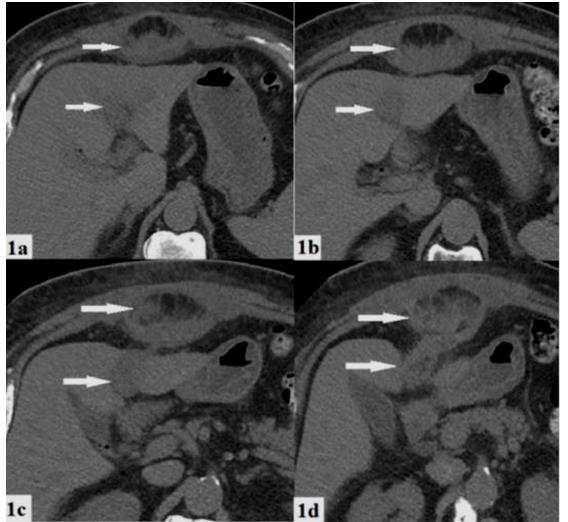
The falciform ligament hematoma is shown with arrows on a non-contrast abdominal CT scan
